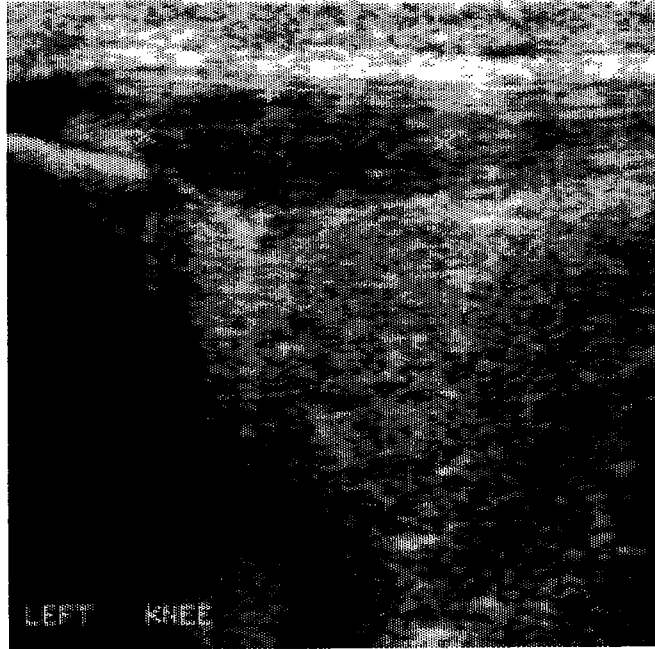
A classic sagittal ultrasound of patellar tendinopathy, with the swollen, hypoechoic area adjacent to the patella.
